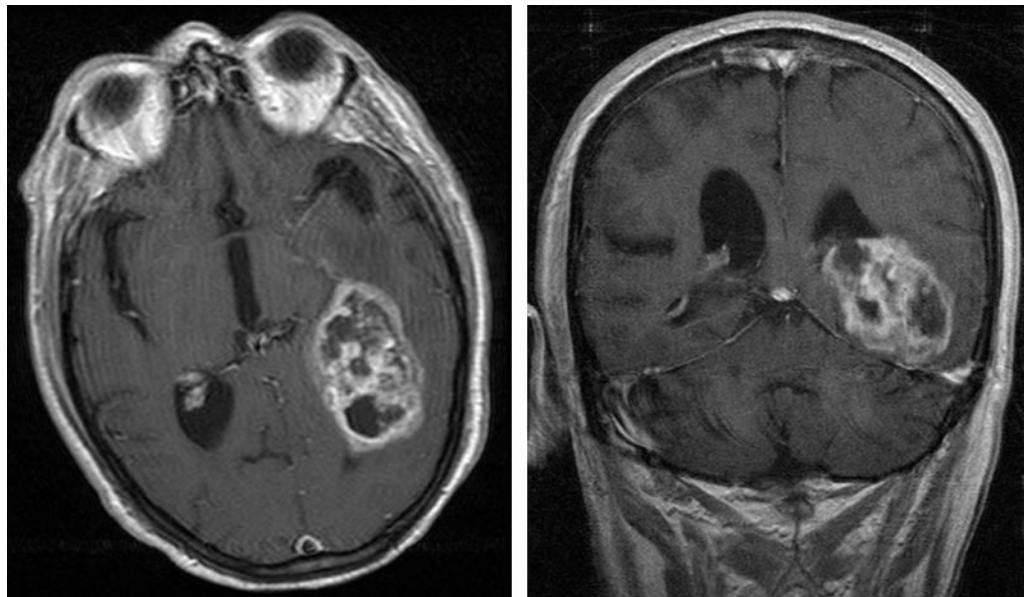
Axial (a) and coronal (b) gadolinium-enhanced T1-weighted MR images demonstrate a heterogeneously enhancing mass with central necrosis centered in the posterior left temporal lobe.
